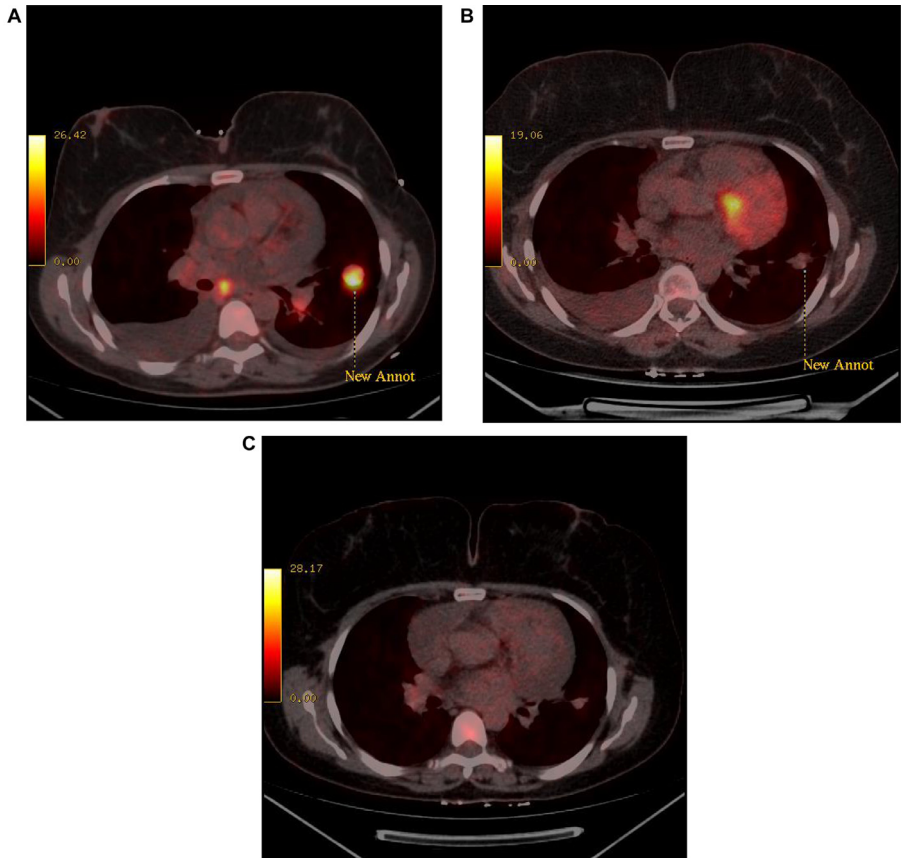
^{18}F -FDG PET/CT scans of the patient. (A) Baseline scan showing primary nodule in upper lobe of left lung (dashed line). (B) Partial response in primary nodule at 10th week of treatment (dashed line). (C) Stable primary nodule and new metastatic lesion in T6 vertebrae at 32nd week of treatment.
